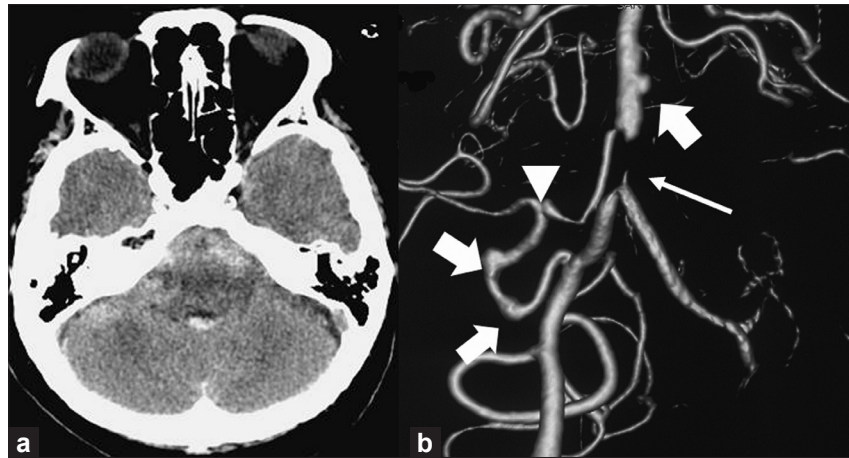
Case 2. (a) CT performed at the time of admission showed diffuse subarachnoid hemorrhage and hemorrhages in the fourth ventricle. (b) 3D-DSA also acquired at admission revealed severe basilar artery (BA) stenosis (long arrow) just distal to the vertebral artery union. There were three arterial dilations (thick arrows): two were in a posterior inferior cerebellar artery (PICA)-anterior inferior cerebellar artery (AICA) anastomosis (arrowhead) and one was in the BA trunk distal to a stenotic site
